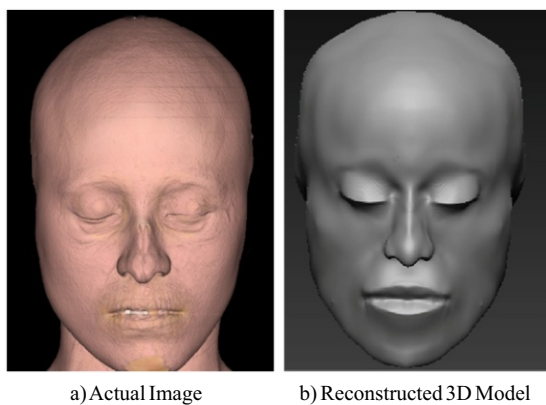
“Resemblance rating technique” for CT photo evaluation.
